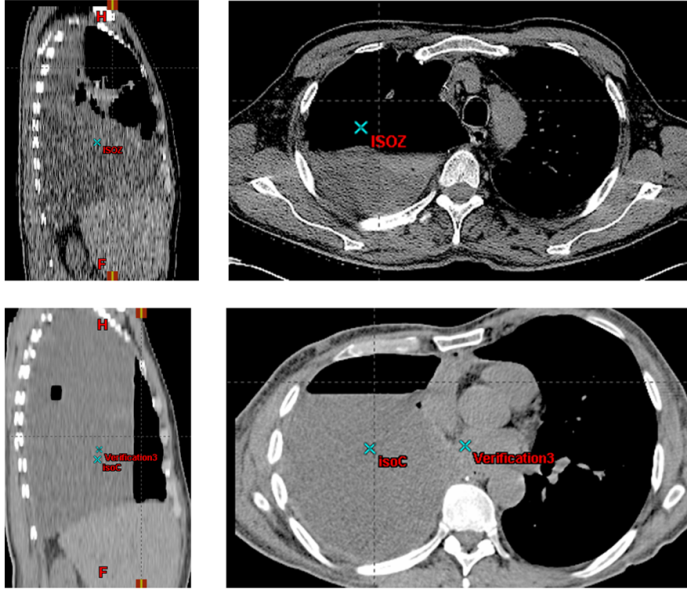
Computed tomography of a right-sided malignant pleural mesothelioma patient 7 days (top) and 47 days (bottom) after extrapleural pleuropneumectomy. Initial air cavity of  $850 \text{ cm}^3$  on Postoperative Day 7 was reduced to  $340 \text{ cm}^3$  by Day 47. Right: transverse image planes; left: sagittal planes.
